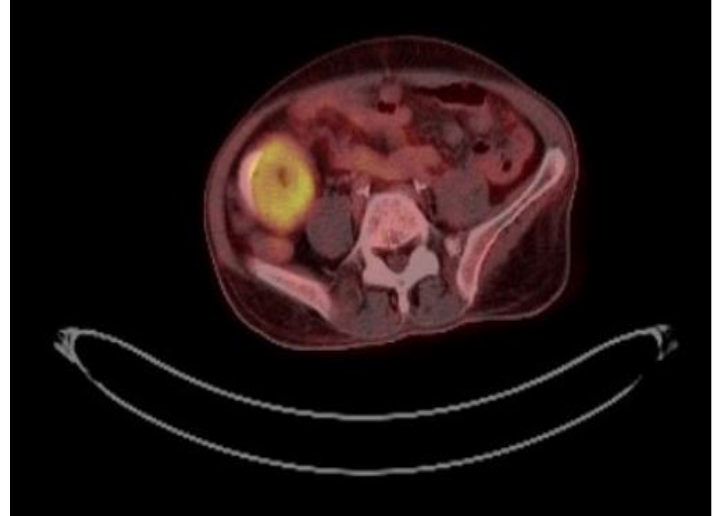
FDG PET/CT scan showing presence of that same mass as FDG avid lesion
